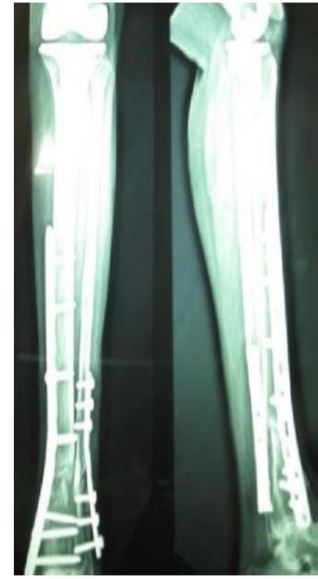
20 Weeks follow up radiograph
